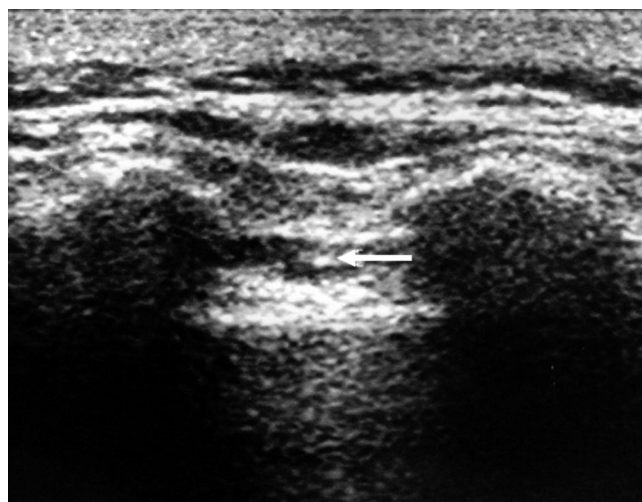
The ultrasound transverse view. Arrow indicates caudal epidural needle.
